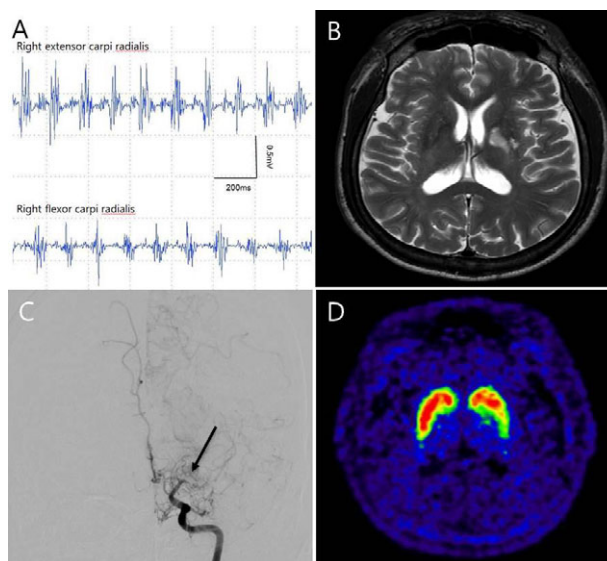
Surface electromyography studies, performed while arms are outstretched, reveal alternating 5-Hz bursts in the right flexor and extensor carpi radialis muscles. (B) T2-weighted axial brain MRI studies show infarctions in the left pallidum and posterior putamen. (C) Cerebral angiography studies reveal stenosis in the left middle cerebral artery (arrow) with well-developed collaterals, compatible with moyamoya disease. (D) [¹⁸F]-FP-CIT PET studies show a punch-out defect in the left posterior putamen, corresponding to the area involved by the infarction.
